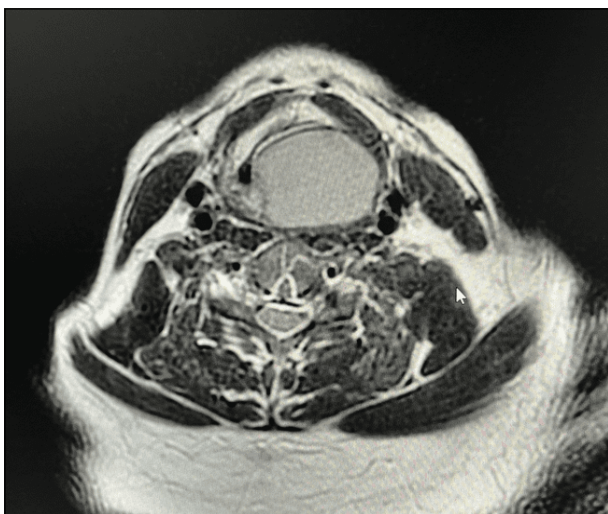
Computed Tomographic axial images of the neck showing the pyocoele
